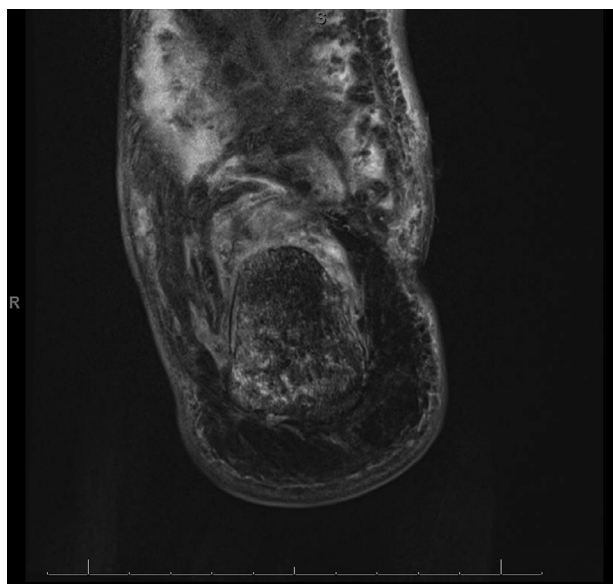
T2 FS (Fat Saturation) MRI sequence of right calcaneus (coronal view) suggesting osteomyelitis.
